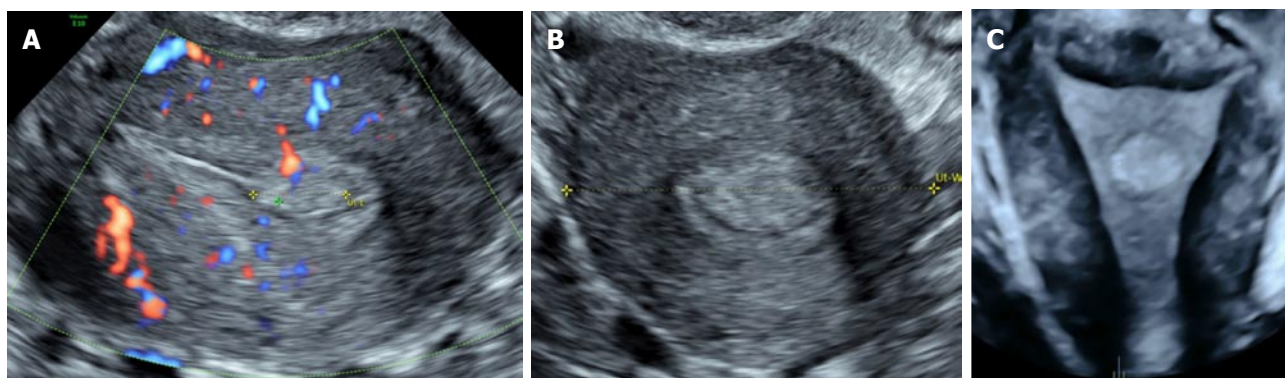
Endometrial polyp. A: Sagittal 2D ultrasound image of an endometrial polyp as identified by a vascular pedicle; B: Transverse 2D ultrasound image of the echogenic endometrial polyp; C: 3D coronal (VCI) ultrasound image showing the endometrial polyp better delineated as an echogenic mass. 3D: Three-dimensional; 2D: Two-dimensional; VCI: Volume contrast imaging.
